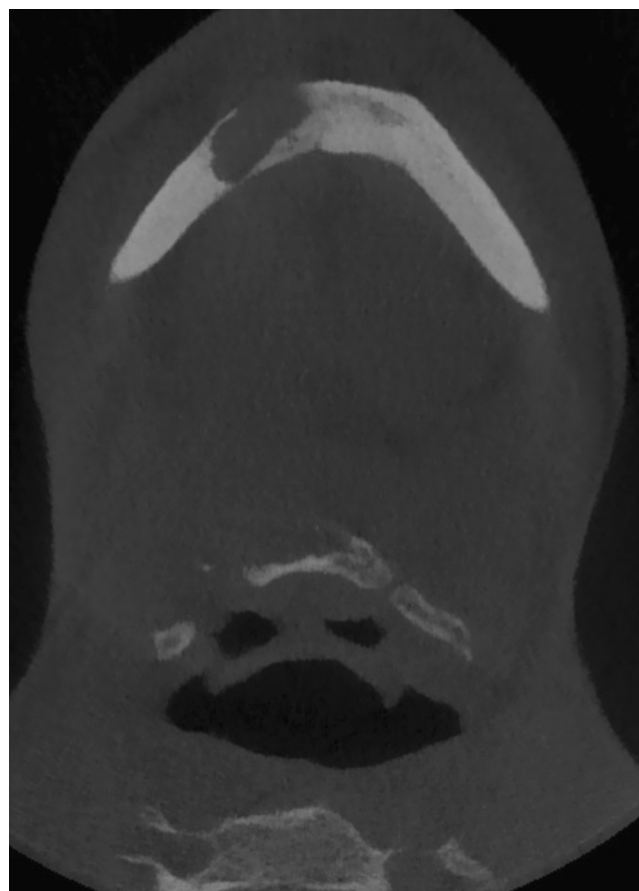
Cone Beam Computed Tomography showing a recurrence on the mandibular symphysis 2 years and a half after the initial diagnosis.
